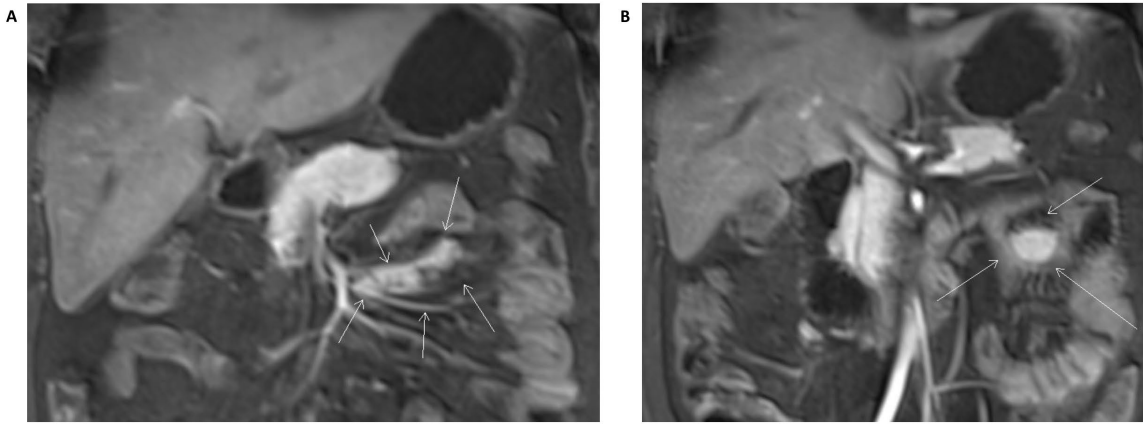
Complete pancreatic duplication. A) Coronal post-contrast T1-weighted images at the arterial phase show the accessory complete pancreas situated in the left hemi-abdomen, slightly more inferiorly than the dominant pancreas. B) The head is associated with the first jejunal loops. Neither the dominant or the accessory pancreas show peripancreatic inflammatory stranding.
